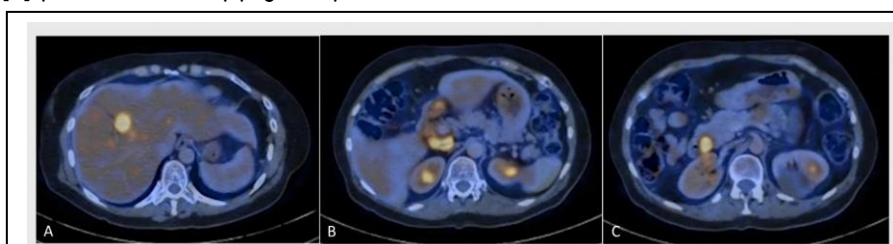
Axial FDG PET-CT images demonstrate 3 hypermetabolic lesions at the three levels of the biliary duct. Primary tumor maximum standardized uptake value is 10 in a 25mm lesion located in the right intrahepatic bile duct at the level of segment 8 (A), 6 in the 20 mm lesion of the proximal bile duct (2cm from the biliary confluence) (B), and 7.4 in the 35 mm lesion at the pre-papillary bile duct (C).
